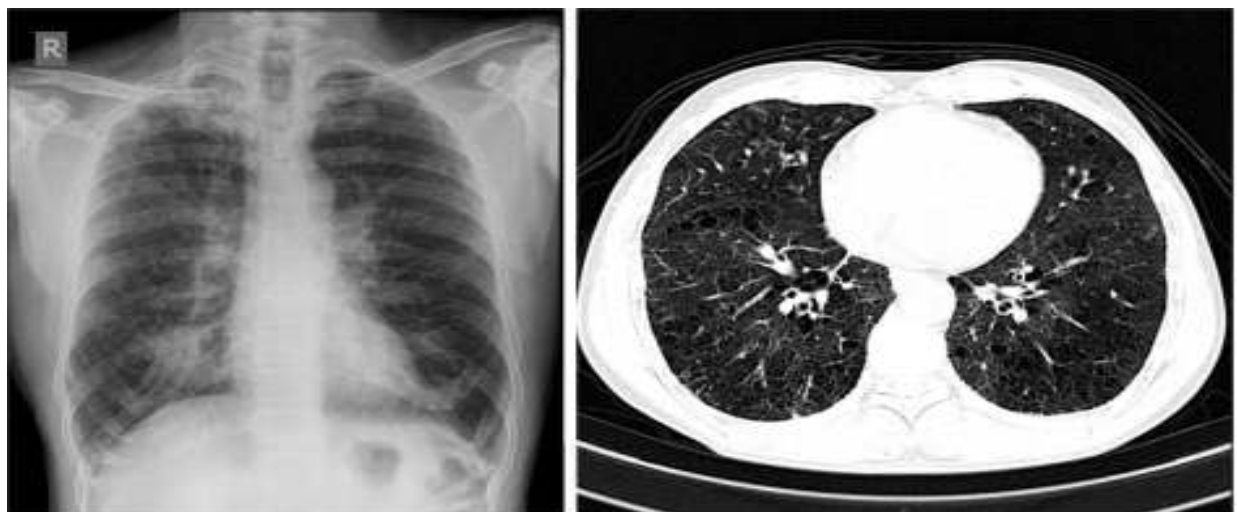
X Ray Chest and HRCT Thorax of a 51-year-old male smoker who was treated as COPD for the last 10 years. He worked in coffee pounding mill for 20 years and stopped that work when he started developing symptoms. X-Ray shows hyperinflation, reticular shadows throughout with coalescence in the right lower zone. HRCT section from the lower lobes shows extensive reticulation, architectural destruction and cyst formation.
